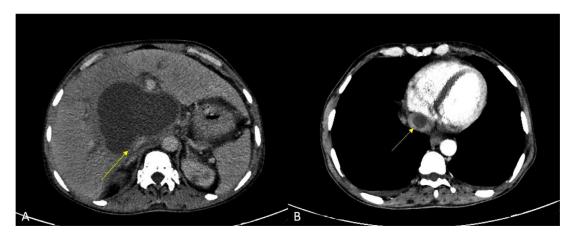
Case 1: Contrast-enhanced CT axial showing (A) compression of the right portal vein (yellow arrow), (B) an eccentric hypodense filling defect in the suprahepatic IVC (yellow arrow).
